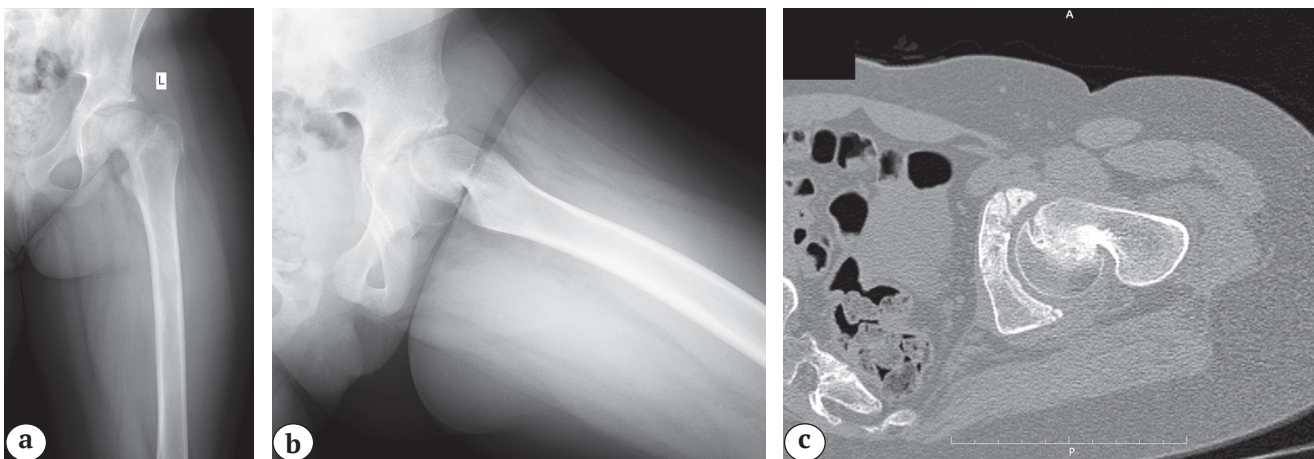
X-rays of hip of female patient 10 y. o., prior to surgical treatment:
